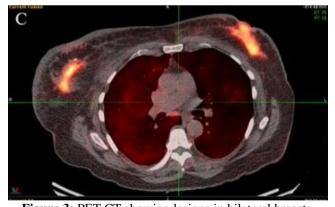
PET CT showing lesions in bilateral breasts.
